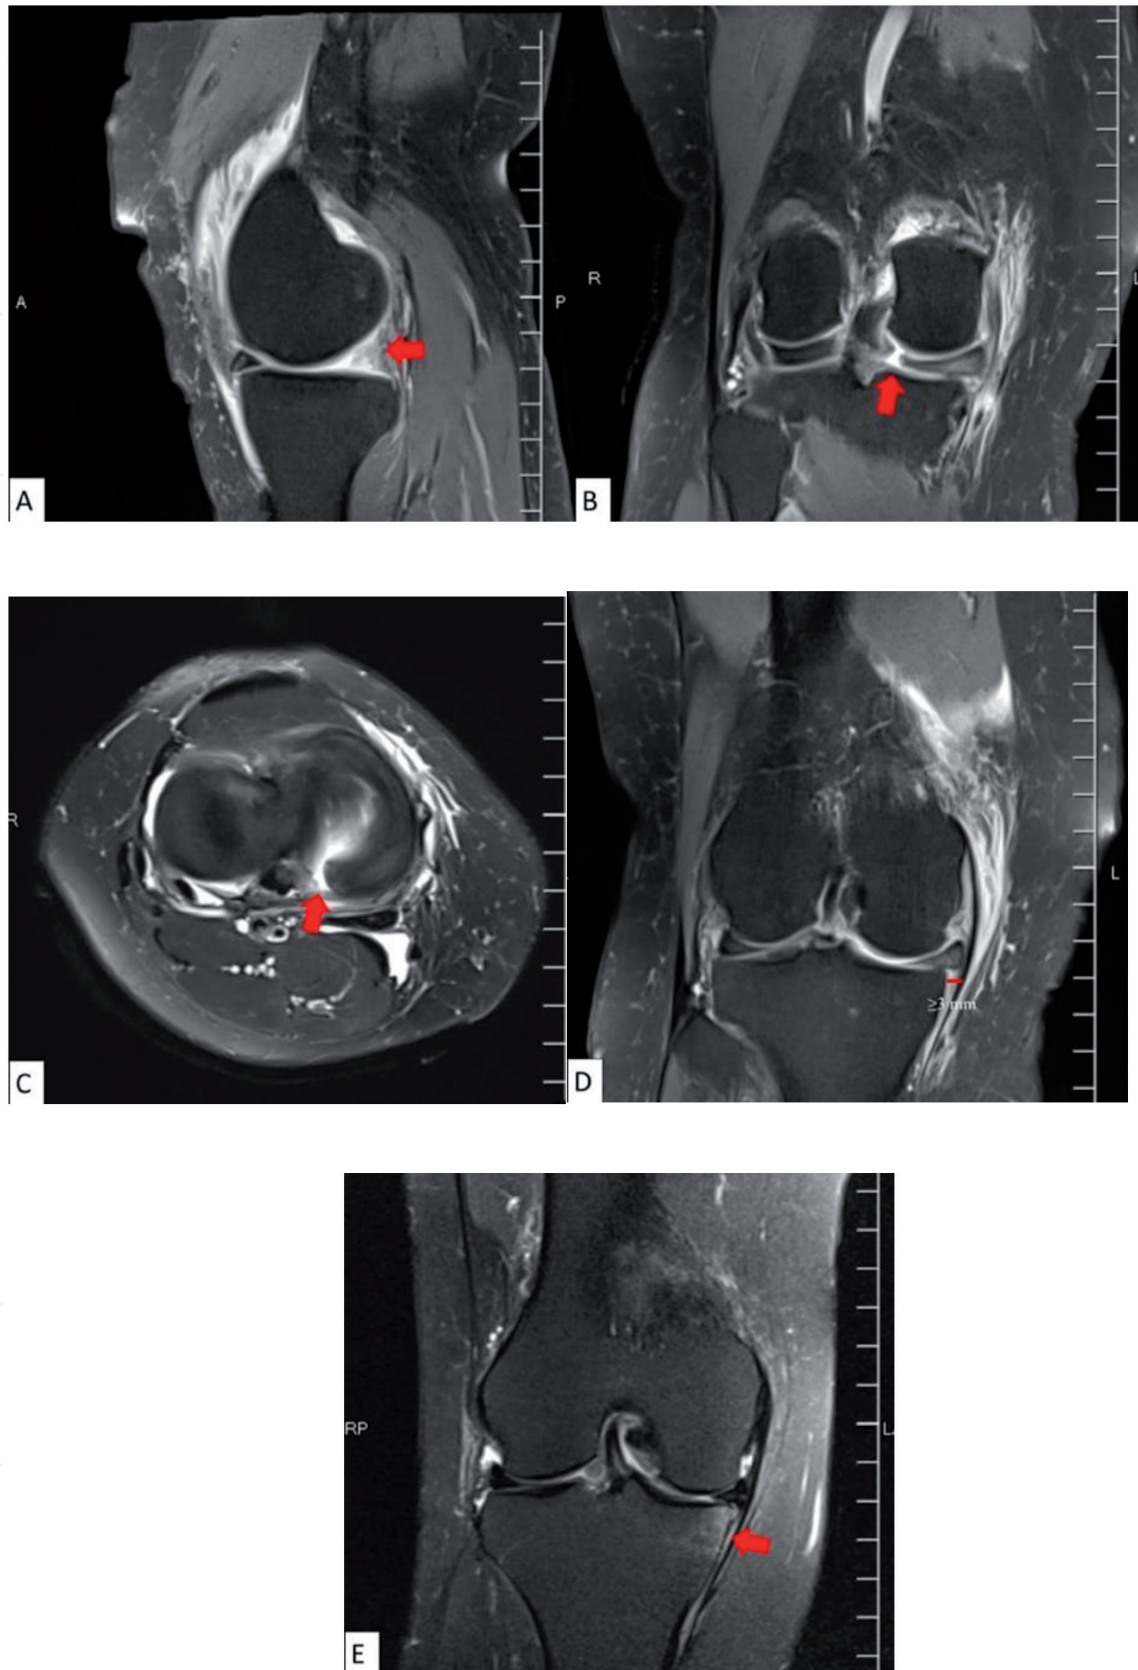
MRI finding of meniscal root tear. A: Ghost sign (absent of posterior horn medial meniscus), B: Cleft sign (vertical linear defect on coronal images), C: Radial linear defect on axial image, D: Medial meniscus extrusion (≥ 3 mm), E: Bone contusion at the articular bearing area which is associated with medial meniscus root tear.
